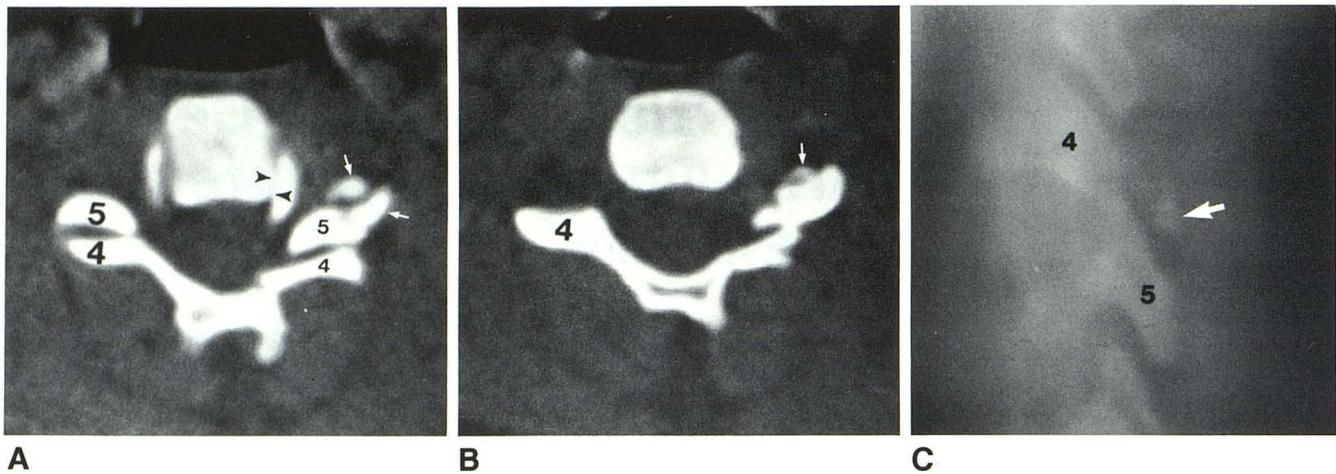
Comminuted fracture of left C4 articular pillar. CT scan (A) shows fracture fragments (arrows) of C4 pillar anterior to superior articular process (5) and abnormal alignment of left uncovertebral joints (arrowheads). A higher
